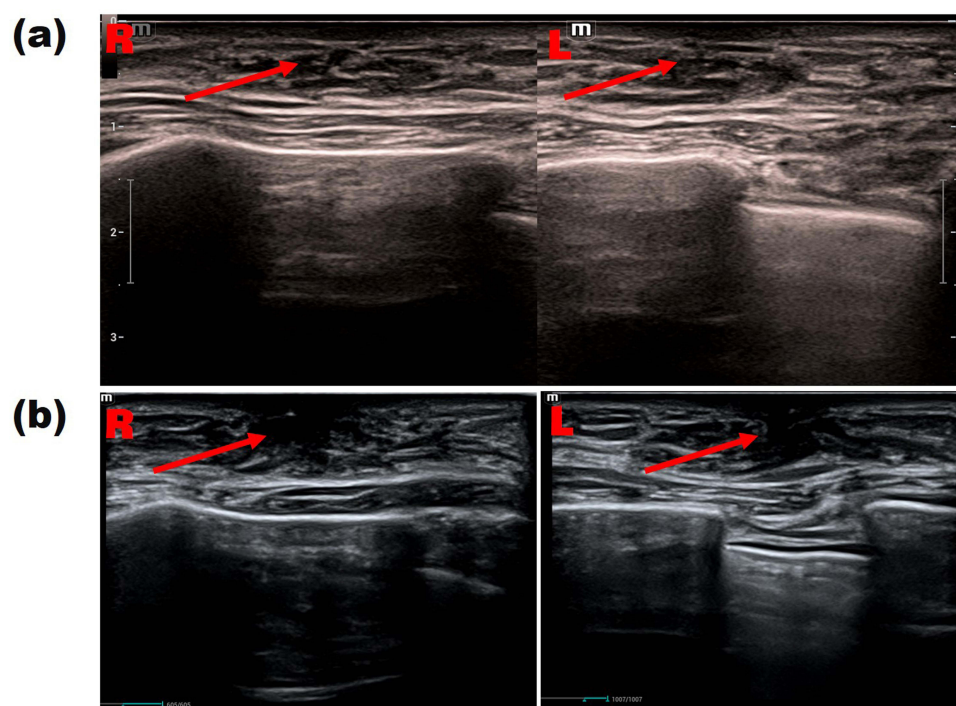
Ultrasonography images show developmental mammary glands. (a) Two weeks after flumatinib; (b) One and a half months after flumatinib. The red arrows indicate enlarged gland.
